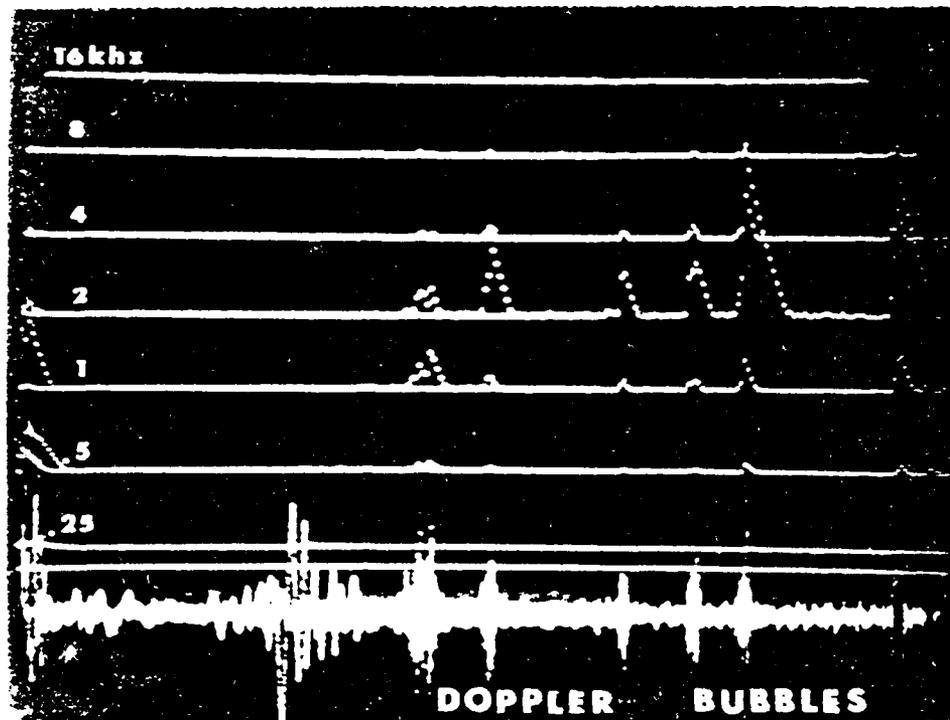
Lower tracing represents the raw Doppler ultrasonic combined flow and blood bubble signal. Upper tracings represent band pass analysis of the signals. The highest amplitude signals seem to represent artifacts on the Doppler signal and do not register in the band passes. Blood bubble signals rising above the Doppler flow signal register on the principal frequency bands.
